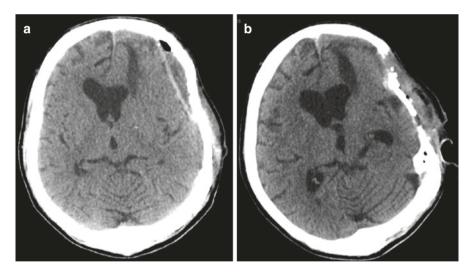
Noncontrast CT head 4 (a) and 5 (b) weeks after cranioplasty revealing progressive ventriculomegaly
